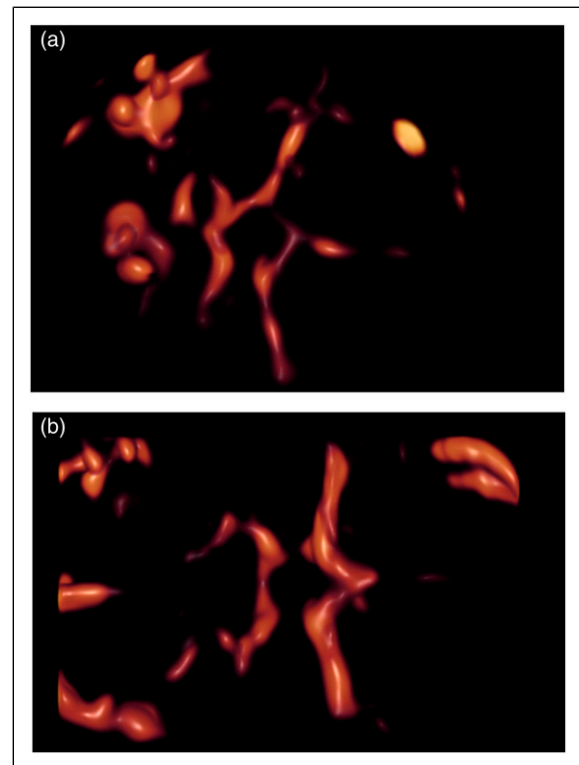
Fetal cerebral three-dimensional power Doppler volume images including the circle of Willis in control (A) and GDM pregnancies (B).
